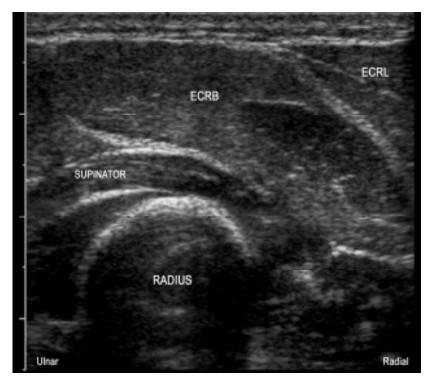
A cross sectional view of the dorso-radial part of the proximal forearm (ultrasonograhy, right arm). The ECRL muscle (extensor carpi radialis longus) is located partly superficial and radial to the ECRB muscle. The supinator muscle insertion to the radius is seen deep to the ECRB muscle. The major tick marks to the left represents 1 cm in between.
